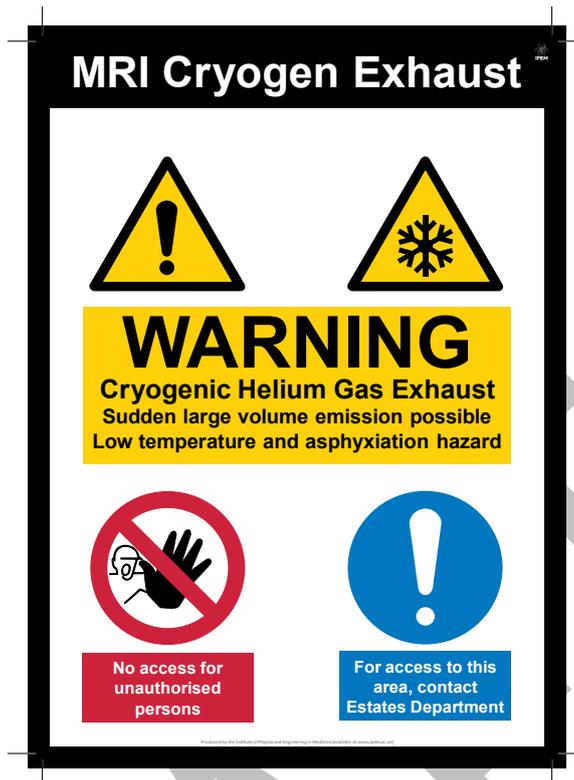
MRI quench pipe outlet warning signage from IPEM MRI safety notices.
